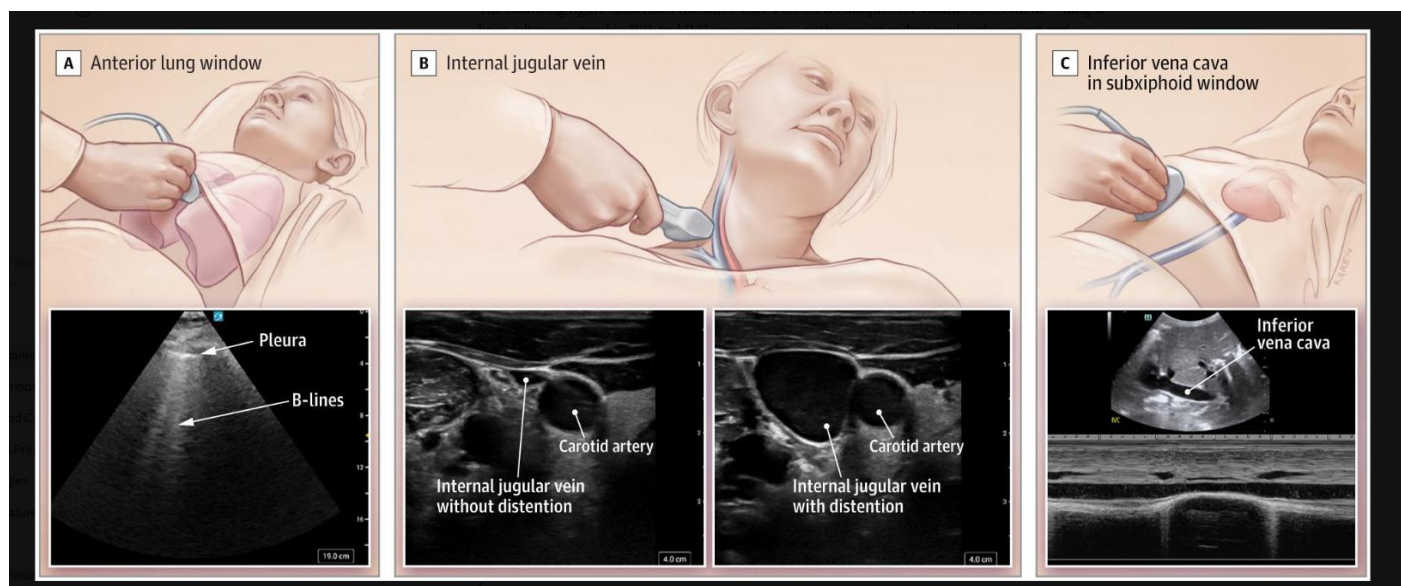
Ultrasonographic findings of pulmonary B-lines, IVC collapsibility and IJ or femoral venous pressure.
